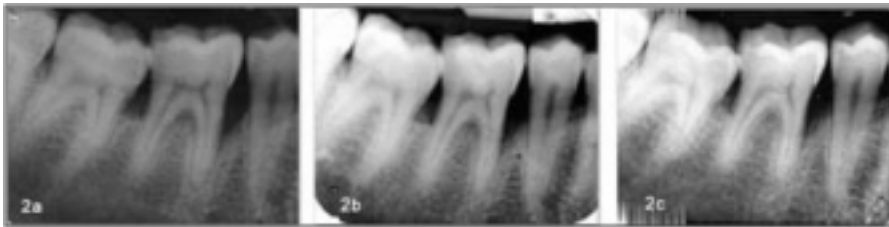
Intraoral periapical radiographs #30; A: Preoperative (baseline); B: 6 months postoperative; C: 9 months postoperative
